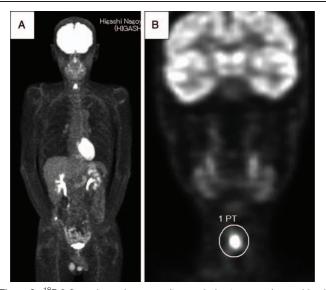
¹⁸F-2-fluorodeoxyglucose positron emission tomography combined computed tomography images (A: whole body, B: volume of interest) of a 66-year-old man with laryngeal squamous cell carcinomas.
